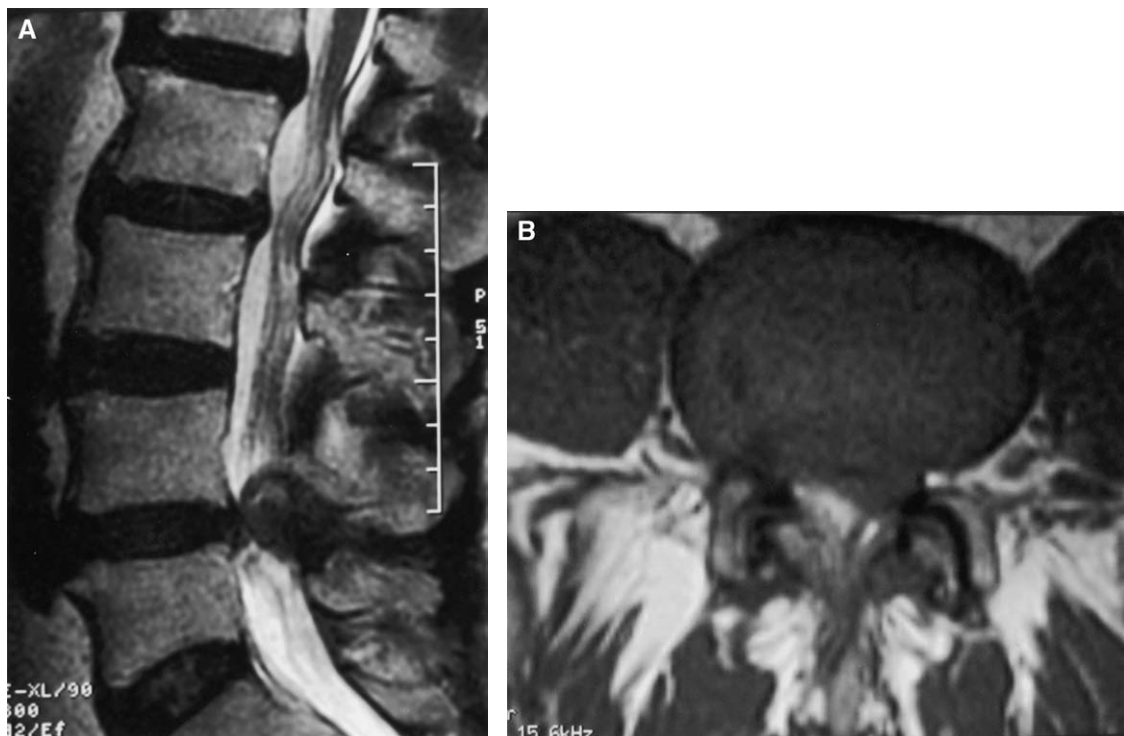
T2-weighted sagittal (A) and coronal (B) MRI scan documenting a large right L4–5 synovial cyst. The cyst projects off the more cephalad aspect of the involved facet joint. This is the preoperative appearance taken 1 week before the acute deterioration, surgical exploration and decompression.
